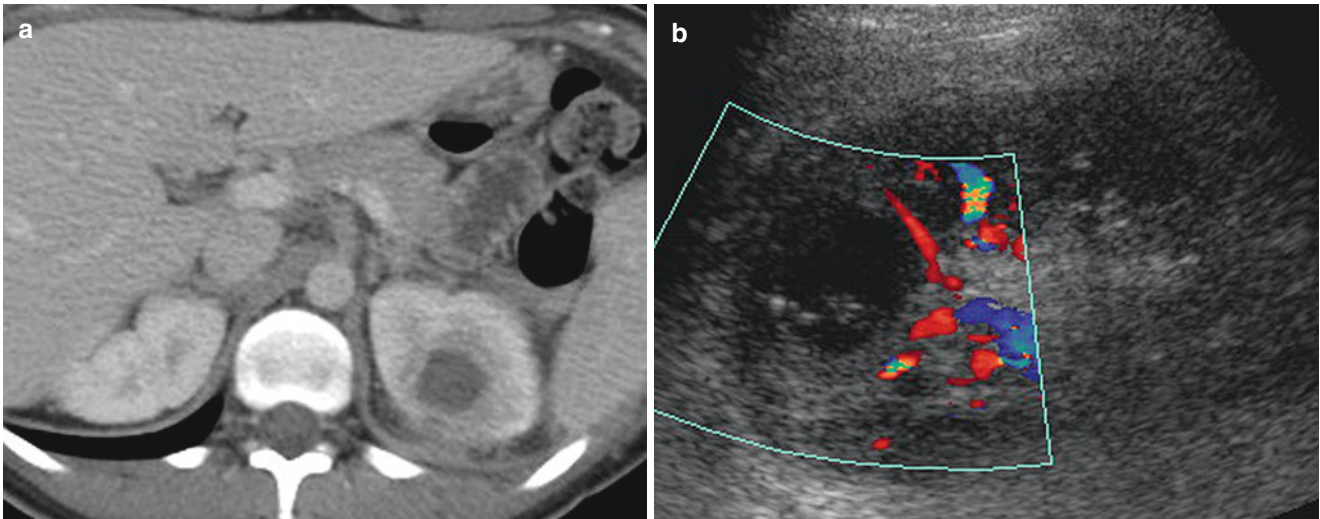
Left renal abscess in a 26-year-old female with left flank pain and fever. (a) Contrast-enhanced axial CT image shows hypodense area in the left kidney with central more hypodense, necrotic core measuring
